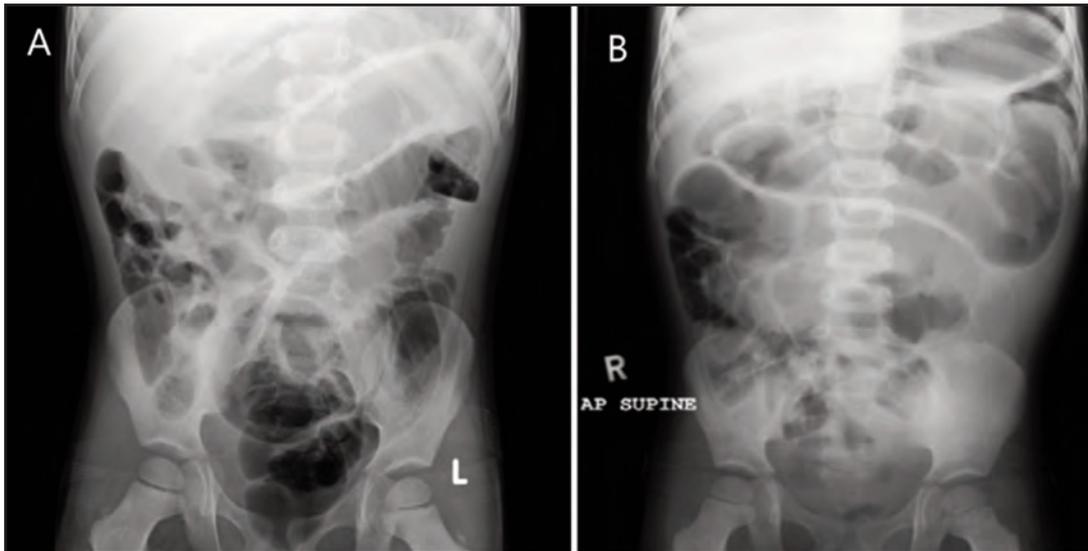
Images of 2 abdominal plain films as the patient's abdominal pain worsens. Image (A) is the abdominal X-ray done in a local health clinic to show dilated bowels with faecal matters and image (B) was done before surgery to show dilated small bowels.
